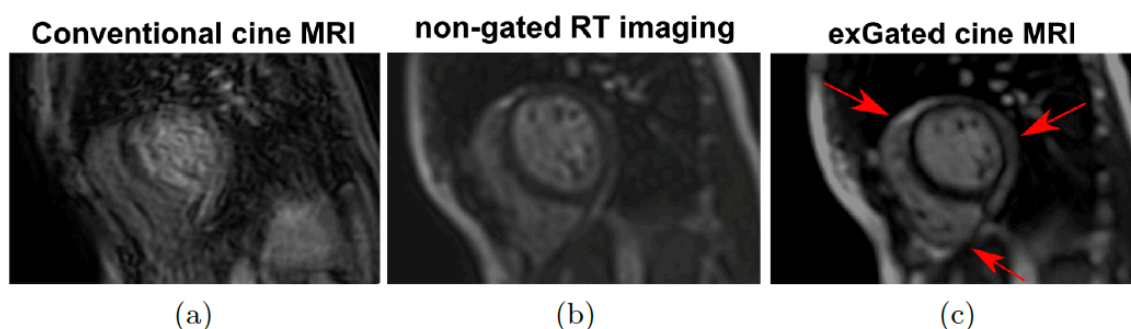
Reconstructed MRI images during exercise: (a) conventional cine MRI, (b) non-gated real-time cine MRI, (c) proposed approach – exGated cine MRI. Arrows denote better delineation of pericardium and RV wall of the proposed method.
